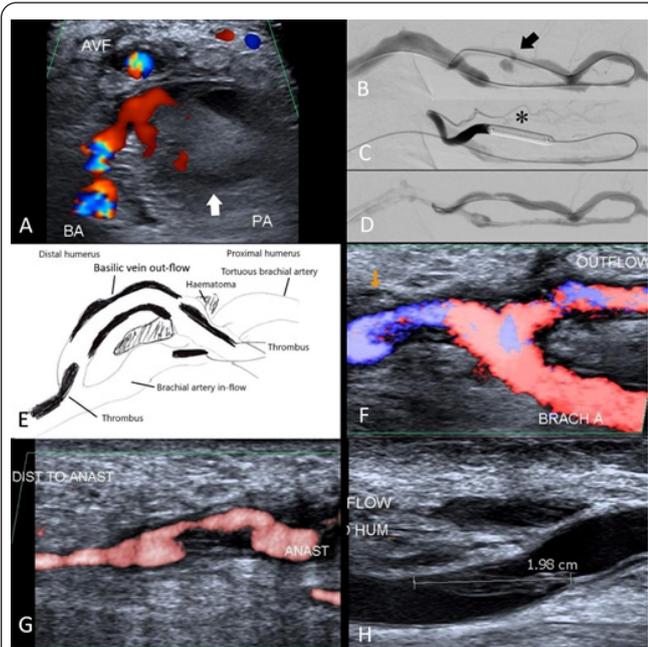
A targeted ultrasound of a left brachio-basilic arteriovenous fistula demonstrates an in-flow brachial artery pseudoaneurysm (arrow) which measures 78 x 25 x 48 mm with a neck of 2.5 x 9 mm (width x length) [Image A (AVF: arteriovenous fistula, BA: brachial artery, PA: pseudoaneurysm)]. There was also a large soft tissue haematoma measuring 136 x 17 mm seen in the vicinity of the pseudoaneurysm, which was exerting mass effect onto the adjacent AVF (Image E). The pseudoaneurysm was subsequently treated with UGTI of 400 IU. On follow-up ultrasound the following-day, there was persistent residual flow at the pseudoaneurysm neck, although the sac was largely thrombosed. It was deemed too high a risk to further inject thrombin under ultrasound guidance alone. Under interventional radiology, the left internal jugular vein (IJV) was punctured and access was secured with a 6-French sheath. Retrograde navigation of the guide wire and catheter into the left subclavian and basilic veins was achieved, the anastomosis traversed, and the catheter secured in the in-flow brachial artery. The subsequent fistulogram not only demonstrates the pseudoaneurysm once again (arrow), but also severe stenosis of the basilic venous outflow over a length of approximately 150 mm, cranial to the anastomosis (Image B). The stenosis was treated with a 6 x 100 mm percutaneous transluminal angioplasty (PTA) Boston Scientific Mustang™ balloon with improvement of the post-plasty angiographic appearance. Subsequently, a 6 x 40 mm PTA Abbott Armada™ balloon was inflated across the in-flow brachial artery [Image C – (asterisk)] to occlude the pseudoaneurysm neck before a further UGTI of 3000 IU into the pseudoaneurysm was performed until cessation of flow was demonstrated (Image D). Following UGTI, several filling defects involving the juxta-anastomotic in-flow brachial artery and out-flow basilic vein were noted (Image E). There was also a tongue of non-occlusive, unstable thrombus measuring approximately 2 cm in length, in the mid-brachial artery, close to the pseudoaneurysm site (Image F, G, and H). Anti-coagulation with therapeutic dose of intra-venous heparin was commenced. Serial follow-up ultrasound imaging demonstrated stable appearance of the thrombosed pseudoaneurysm, reduced volume of the clot burden, whilst the anastomosis and outflow venous limb remain patent.
